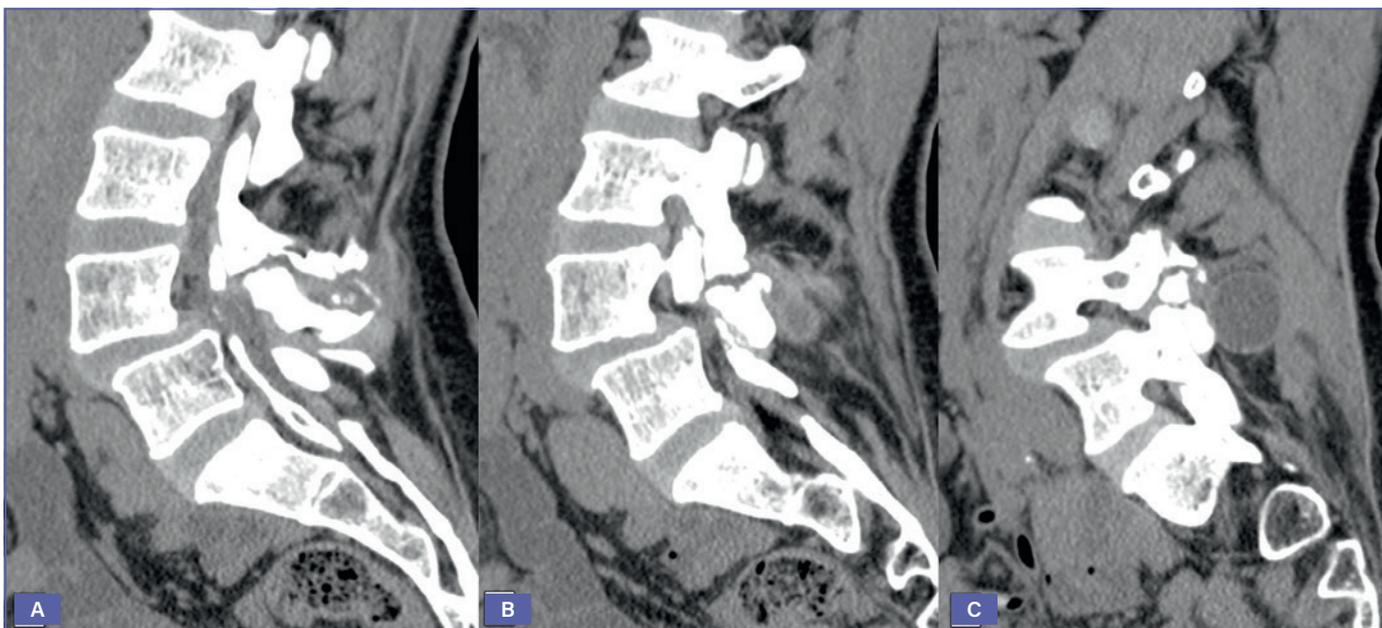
(A,B,C). Sagittal CT-scan from medial to right lateral showing arachnoiditis ossificans and pseudomeningocele.
